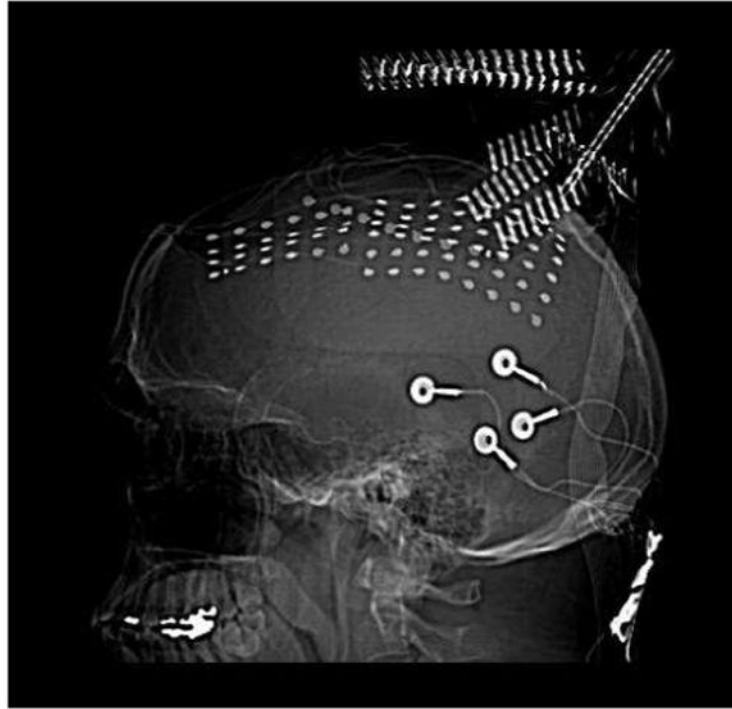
CT image of the implanted grid electrodes. The two grids ($6 \times 8,4 \times 6$) and one medial strip (1×8) implanted in the patient for monitoring.
